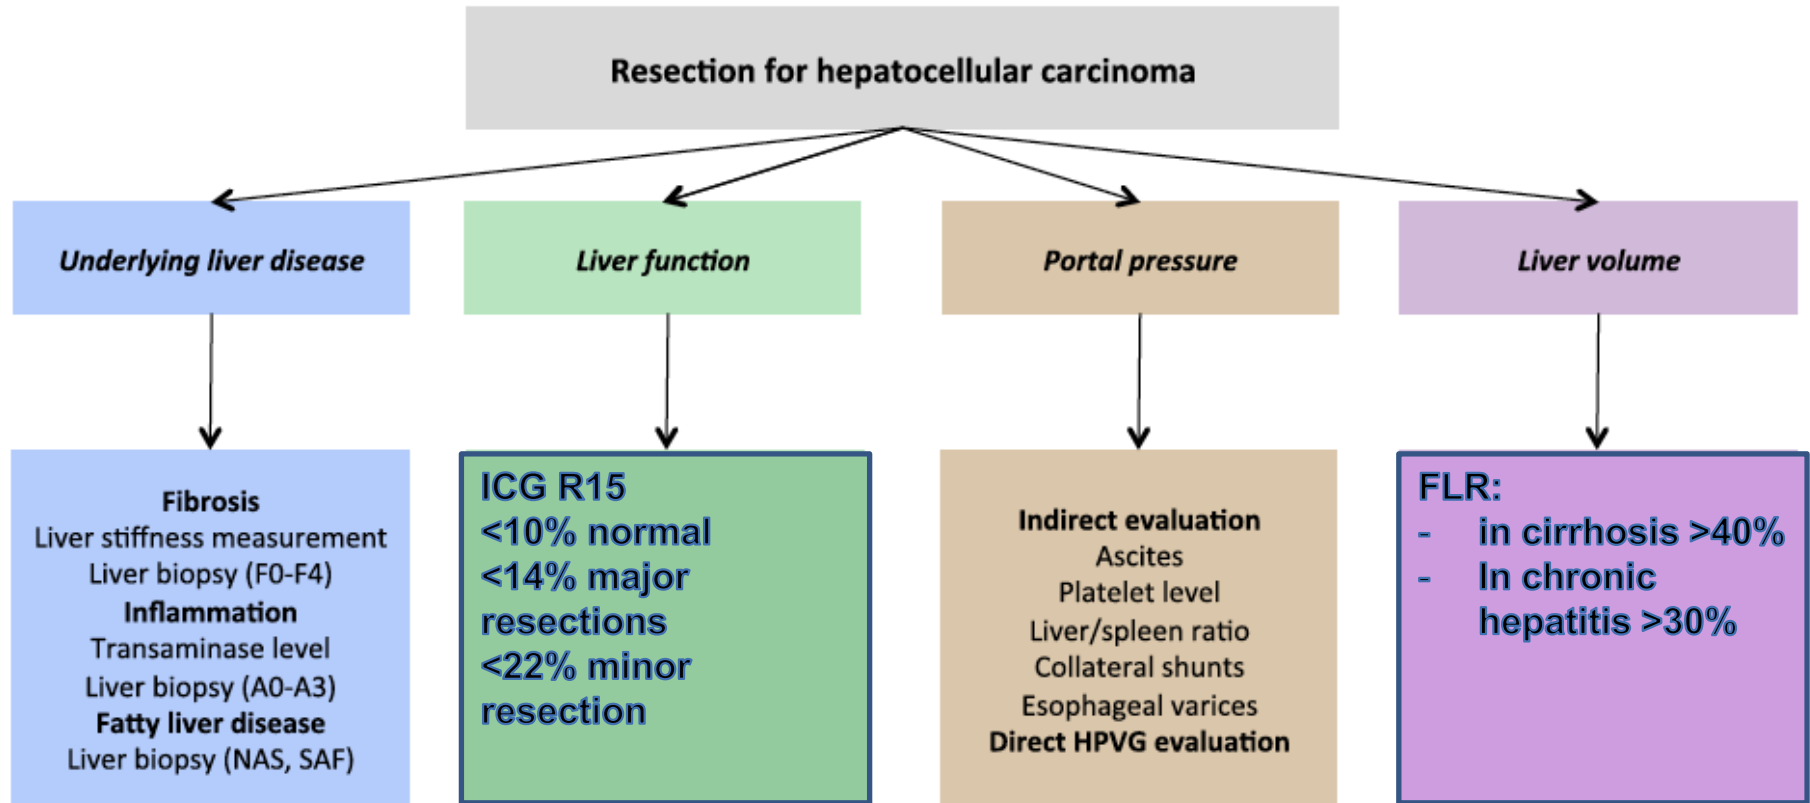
Evaluation of the underlying parenchyma's status and function. NAS: Non-alcoholic fatty liver disease activity score; SAF: Steatosis, activity, fibrosis; ICG: indocyanine green; PVE: Portal vein embolization; HPVG: Hepatic vein portal vein gradient; CT: Computed tomography; FLR: Future liver remnant; TLV: Total liver volume.
